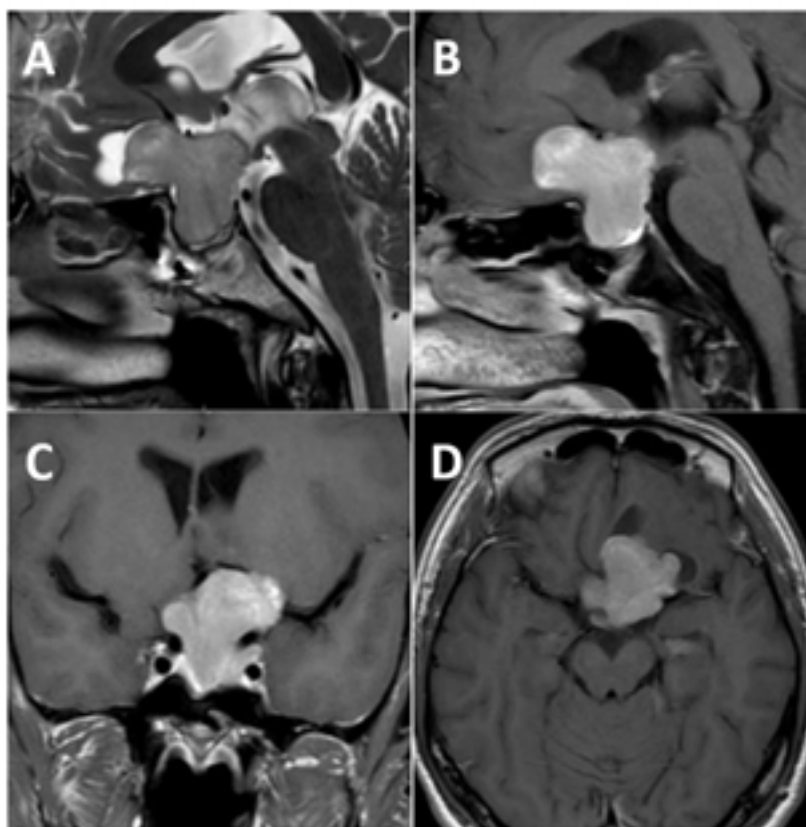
Preoperative MRI showing tumor asymmetry.
